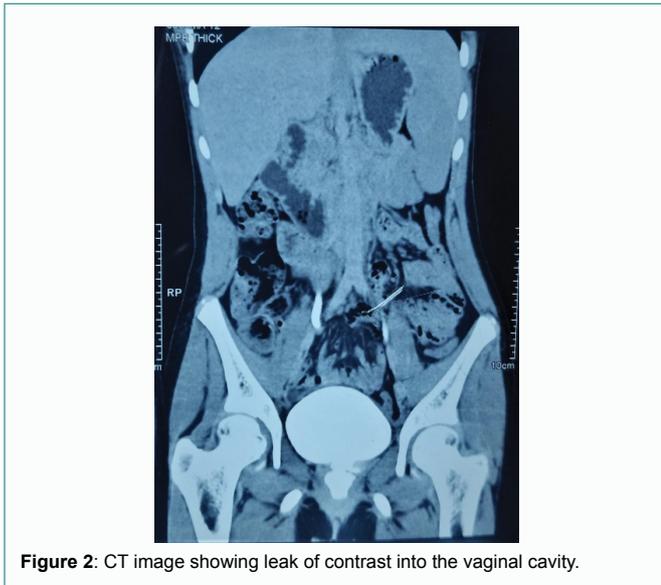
CT image showing leak of contrast into the vaginal cavity.
